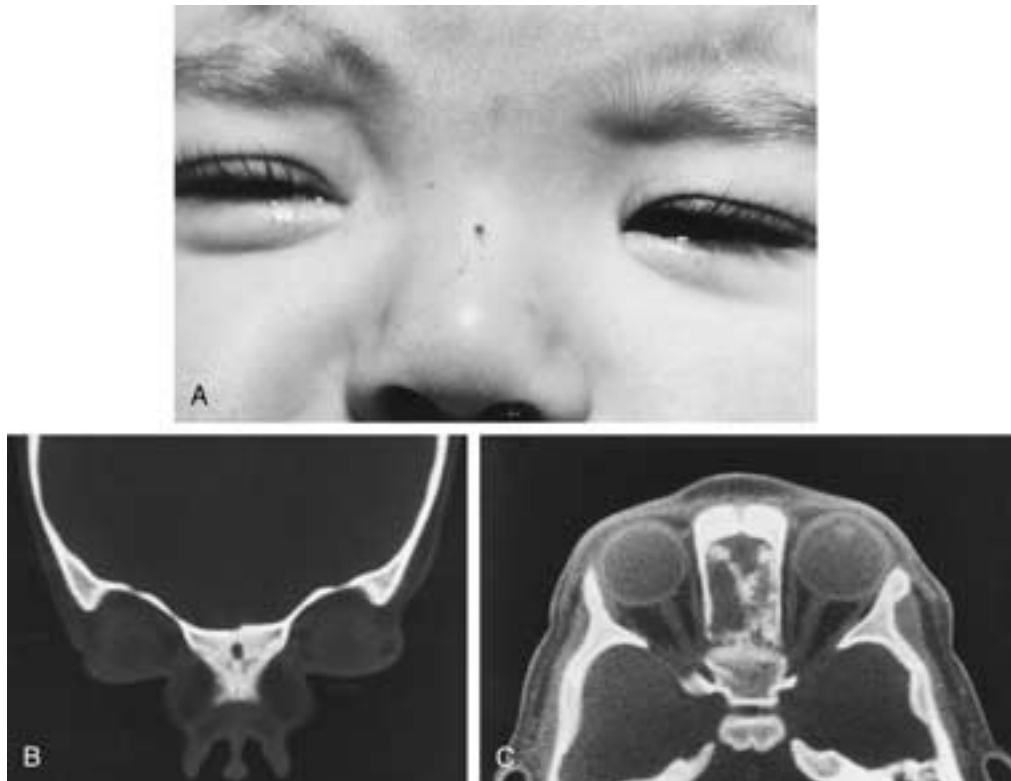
Nasal dermal sinus with intracranial extension. A, Frontal view of a 1-year-old girl shows a small tuft of hairs protruding from a midline dermal sinus on the dorsum of the nose. B, Direct coronal CT. A well-marginated canal penetrates between the nasal processes of the frontal bones. C, Axial CT scan reveals a large foramen cecum with anterior grooving of the crista galli. At surgery the dermal sinus tract and extranasal dermoid were traced upward through the foramen cecum into a 2 to 3 cm intracranial dermoid. This extended intradurally but did not attach to brain. A second “arm” of the intranasal dermoid passed posteriorly toward the sphenoid bone.
